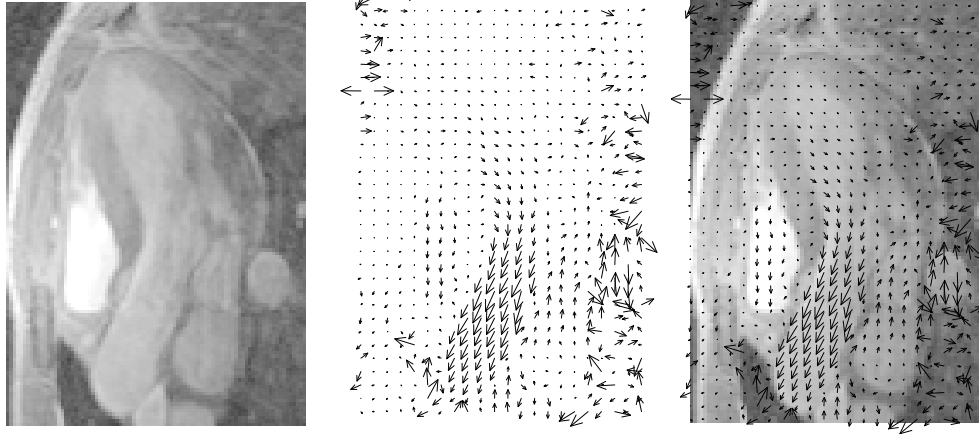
Images from a cardiac MRI with velocity encoding. Top: the modulus image, middle: the velocity image with in-plane velocity components shown as vectors, bottom: velocity image superimposed on modulus image. The anatomy of the heart seen on the MRI is explained in Figure 6.5.
